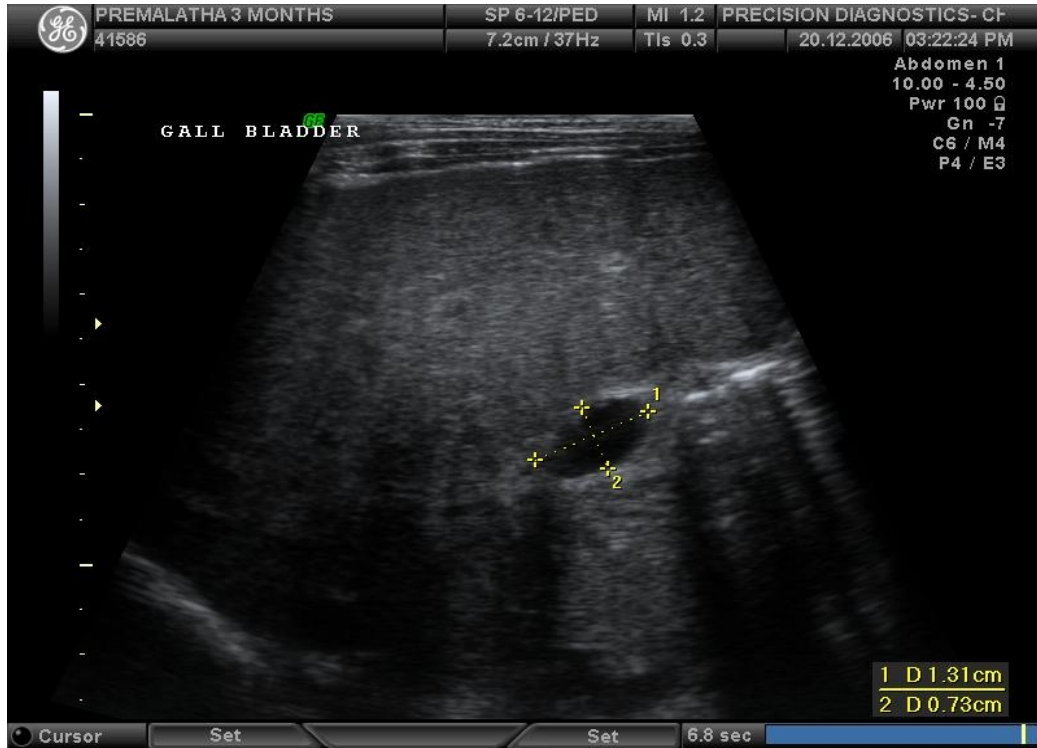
Ultrasonogram showing abnormal gall bladder
